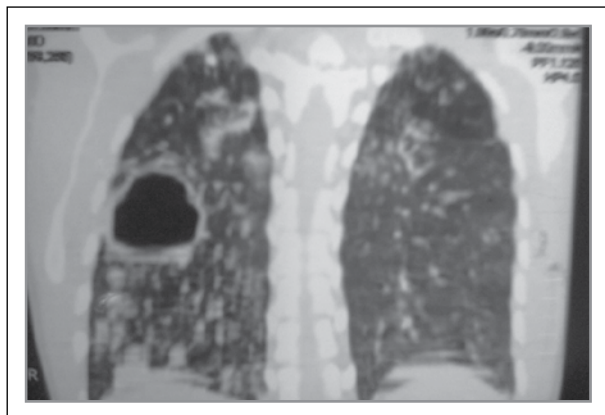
Axial chest CT with contrast showing residual cavity in right upper lobe
